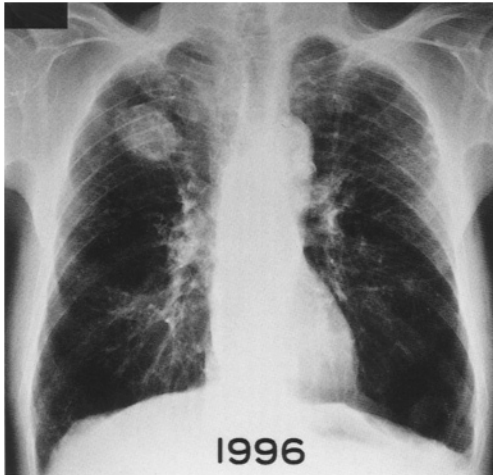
A PA chest radiograph reveals a few numbers of small rounded opacities and irregular opacities in both upper lung zones. A well-defined mass, 4 cm in diameter, is noted in the right upper lobe. Pulmonary vessels have become sparse and overinflation of the lung is obviously identified. The radiograph is read as 1/1, p/s with symbol ca according to ILO classification
